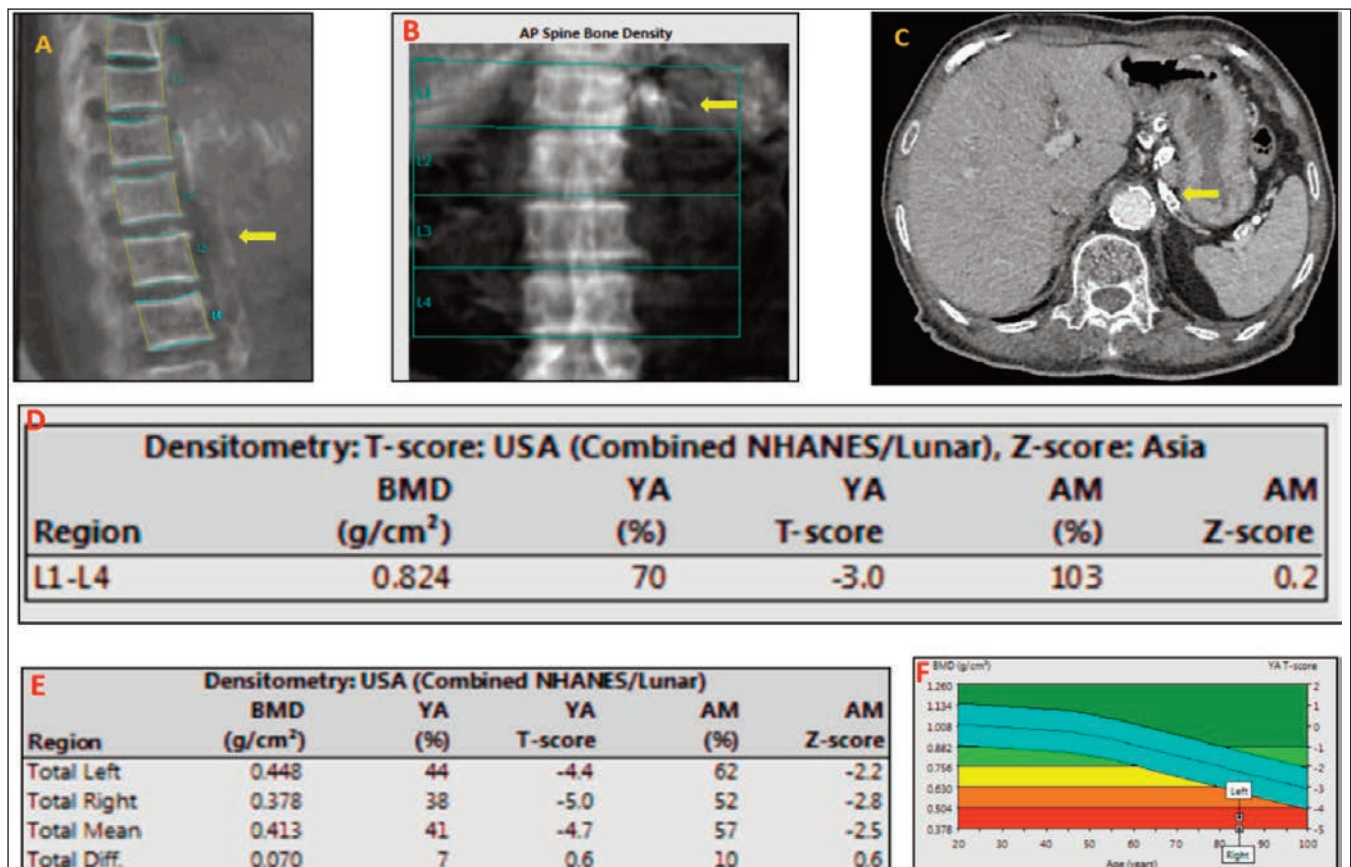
A) Lateral vertebral assessment on DXA showing calcifications of abdominal aorta (Yellow arrow), B) Anteroposterior spine image; radio-opaque density in the left paravertebral region (Yellow Arrow), C) Axial computed tomography images showing splenic vessels calcification (Yellow arrow), D, E) T-score values of lumbar vertebra and bilateral femoral bones. F) Graphical BMD representation in the bilateral femur.
